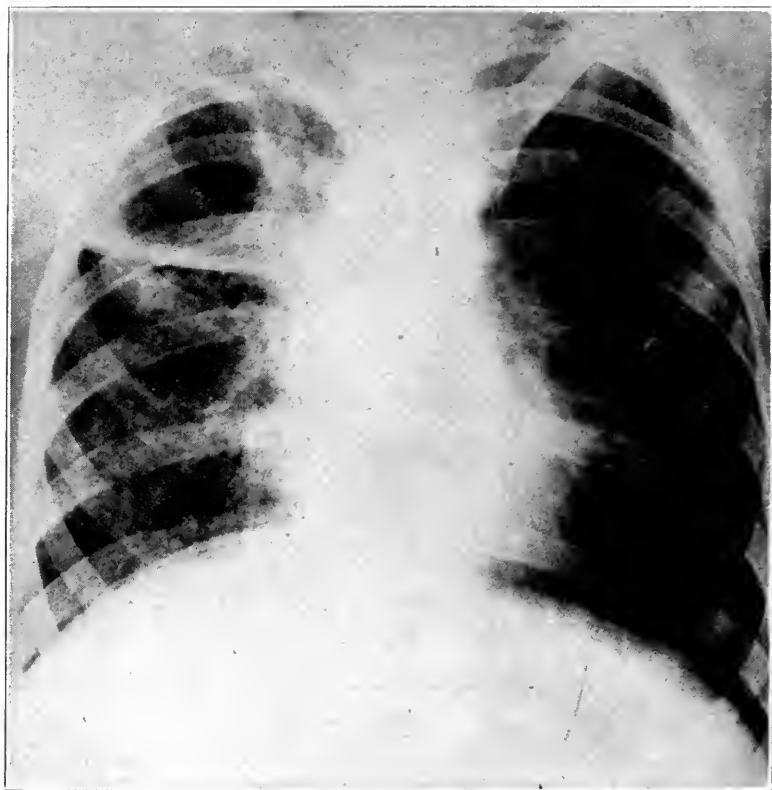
Case 960. Roentgenogram of the lungs in an advanced unilateral case. The original upper right lobe involvement is demarcated strongly and sharply by fibrous and pleural interlobar thickening. The large cavity has a heavy fibrous outline.
